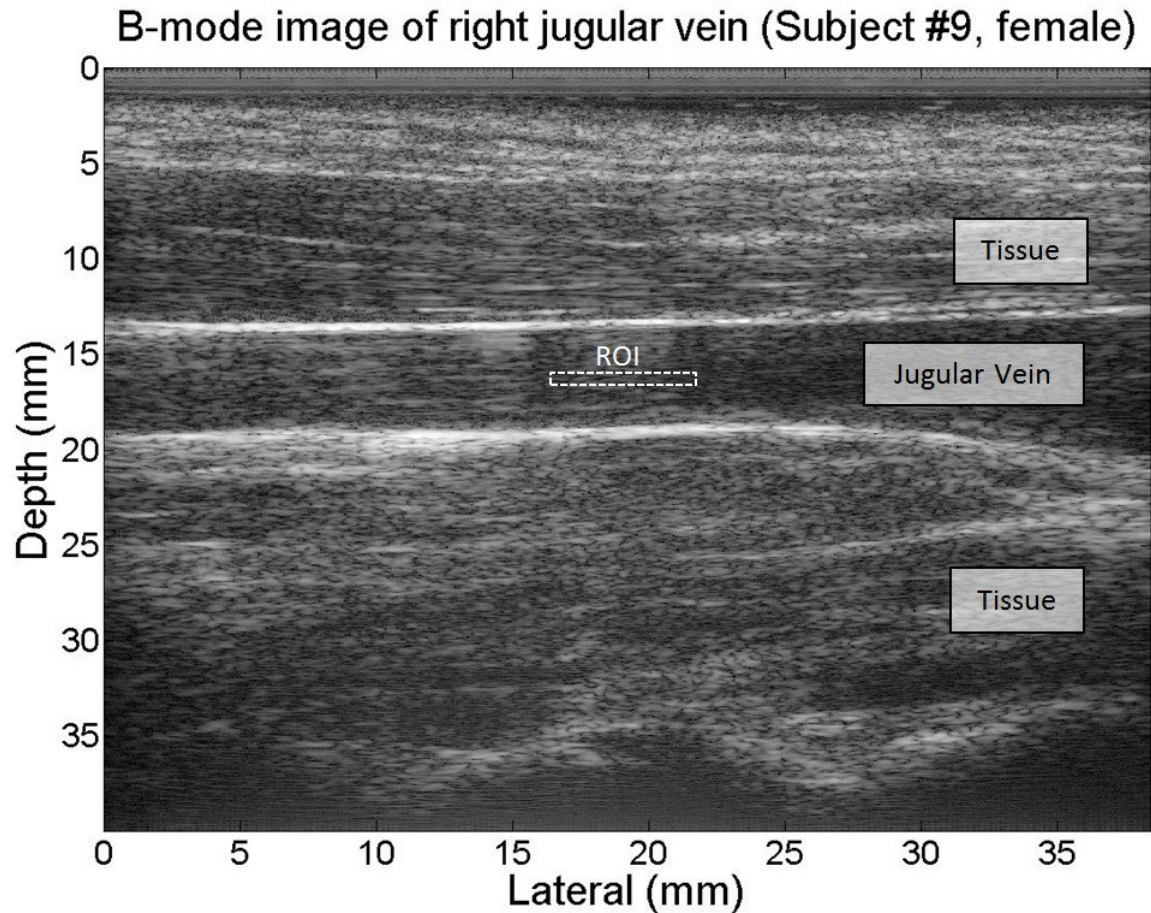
Sample image of the right jugular vein of a female human subject collected by Siemens Antares Ultrasound Imaging System, the scan velocity is 90 cm/s. The jugular vein is corresponding to the dark area at the depth from 13 to 20 mm.
